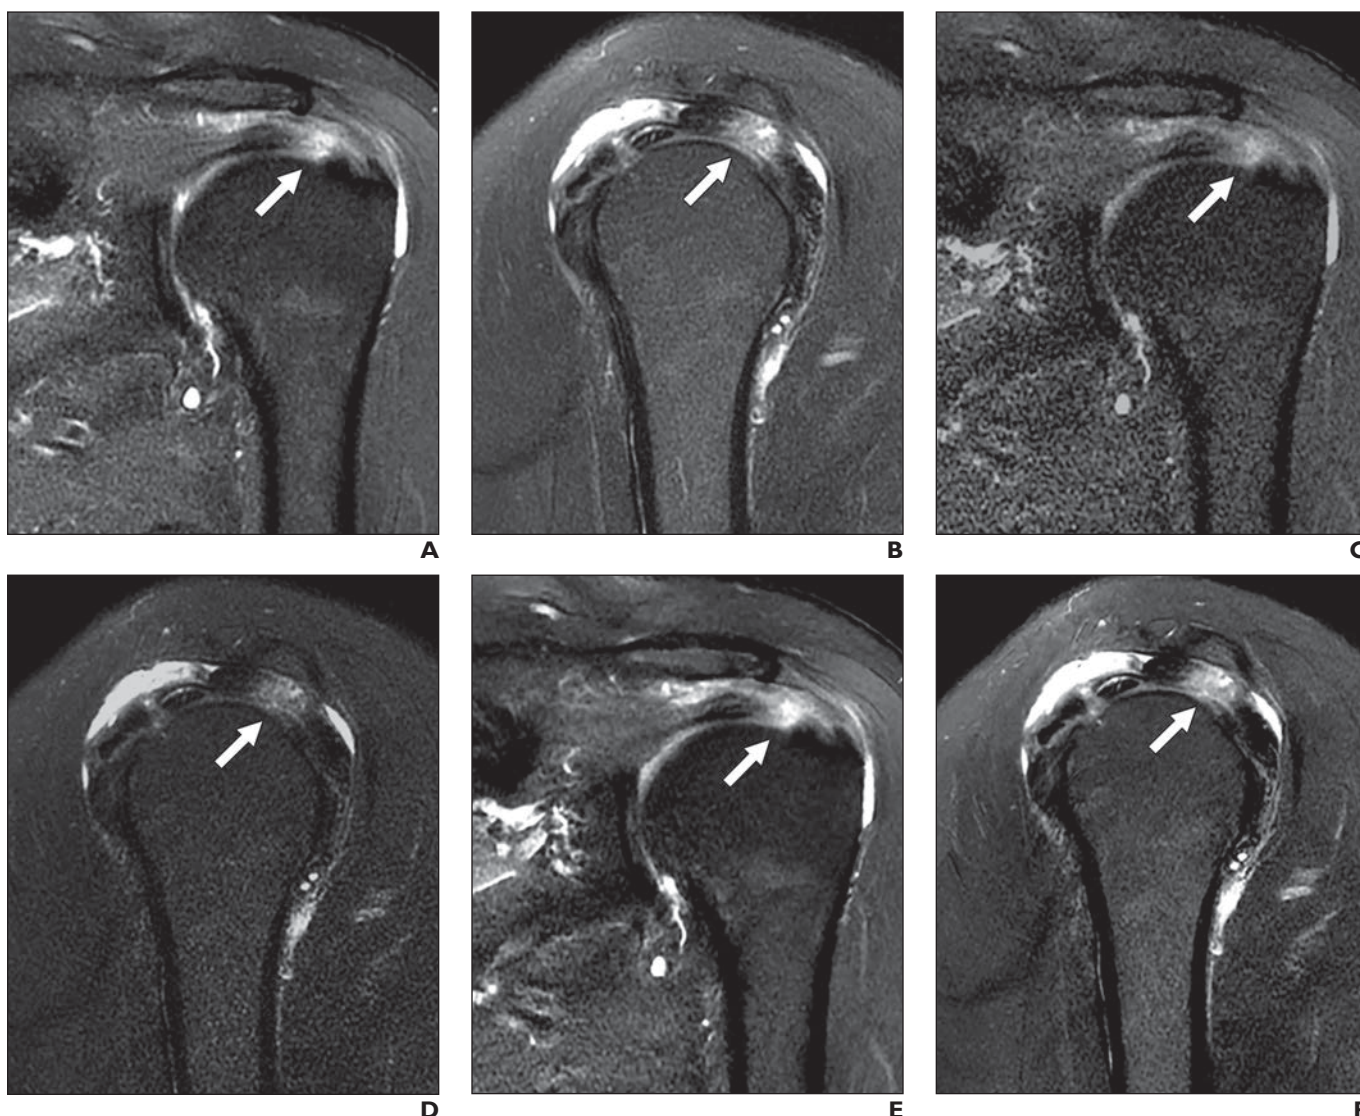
65-year-old woman with left shoulder pain who underwent MRI.
